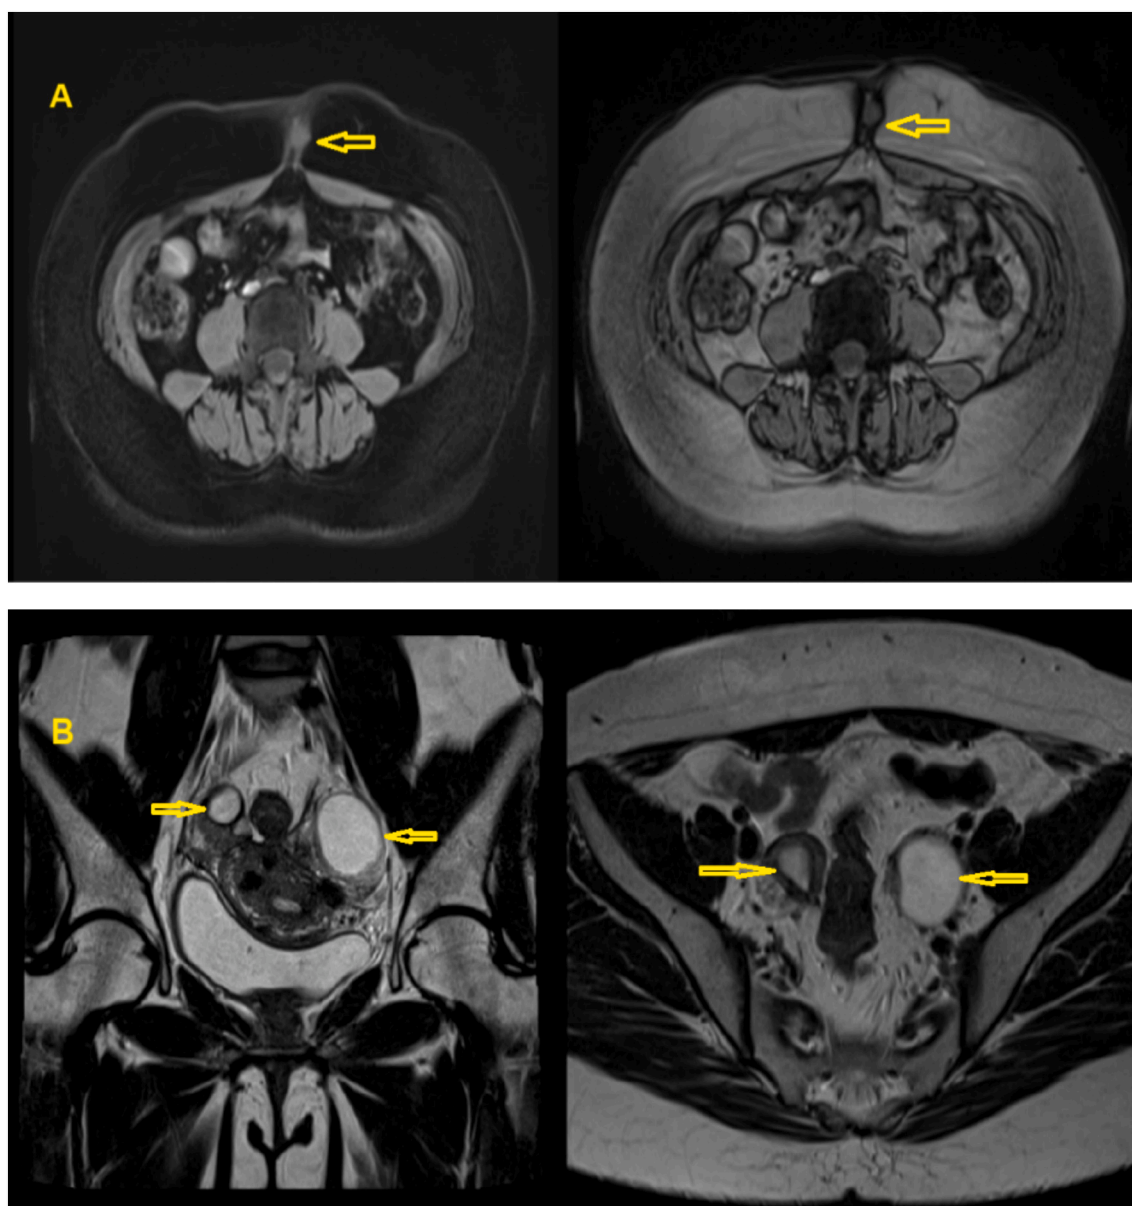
A: An abdominal MRI (axial view) revealed an ill-defined enhancing mass (indicated by yellow arrow) measuring $3 \times 4 \times 6$ cm located along the right anterior abdominal wall and was connected to a sinus tract extending inferiorly to the suprapubic region but did not communicate with the peritoneal cavity, findings suggestive of endometriosis.
